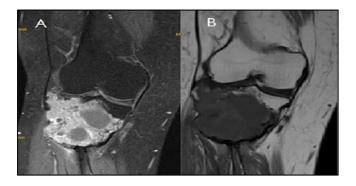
(A and B): MRI knee T1 contrastenhancement of solid component with multiple cyst within T1 image-hypointense solid area with multiple cyst within.
